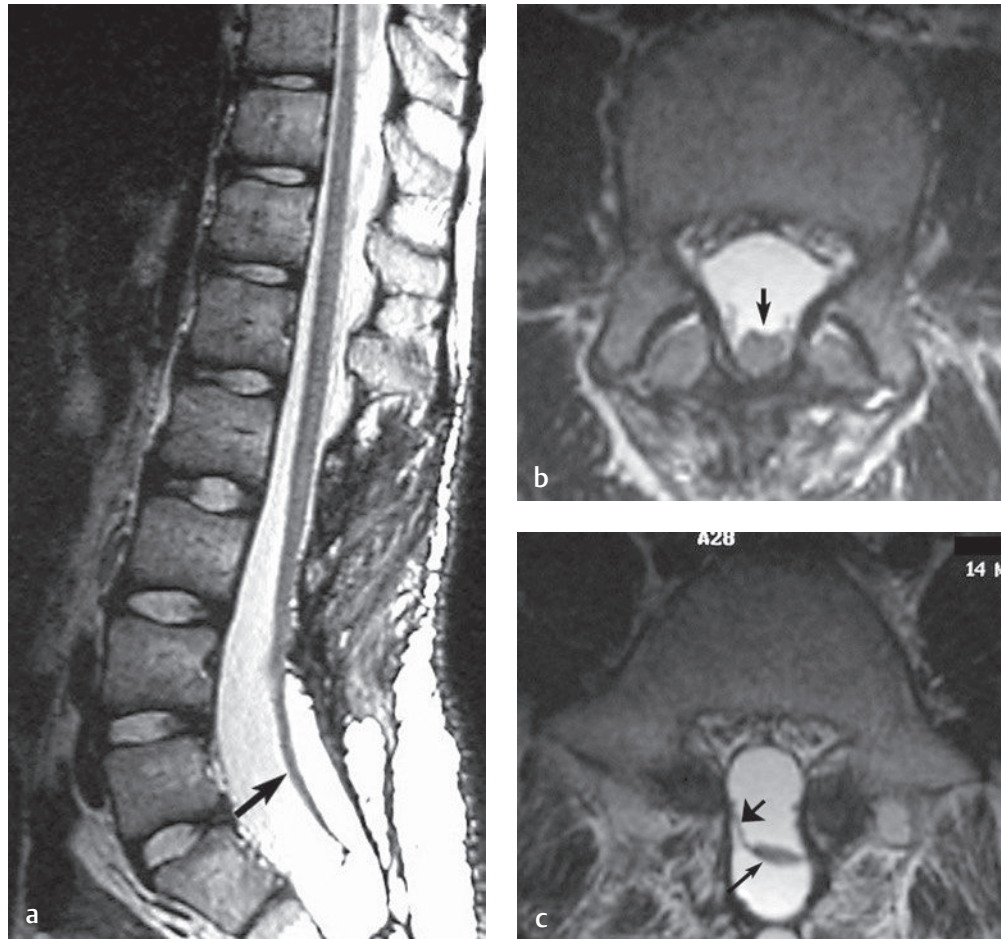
This 14-year-old boy had a history of lipomeningocele. After surgical resection, he developed bowel and bladder dysfunction and new lower extremity paresthesias. (a) A sagittal T2-weighted image shows the cord to extend to approximately the L4 level and the filum terminale to extend to the S1 level (arrow), compatible with a tethered cord syndrome. (b) An axial T2-weighted image at the L4 level shows the cord to be located posteriorly within the thecal sac (arrow). (c) An axial T2-weighted image at the L5 level shows the placode (arrow with a small head) with a right-side nerve root coursing anteriorly and laterally (arrow with a large head).
